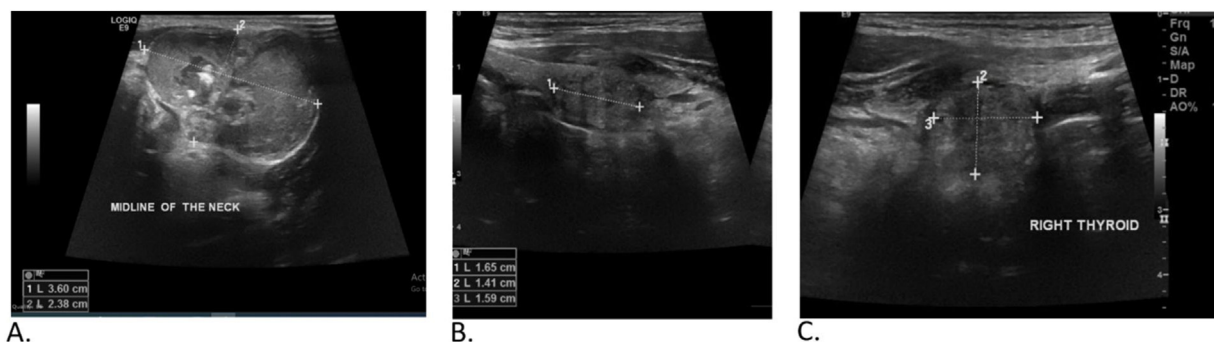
Ultrasound of the neck showing A. Midline neck swelling (TGDC); B & C. Right thyroid lobe nodule (TI-RADS 4).
